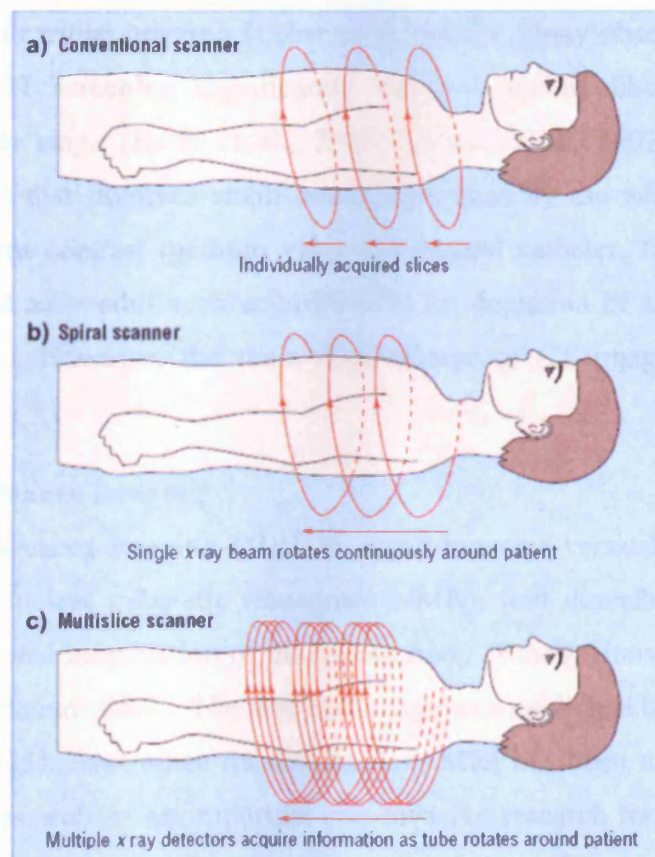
Different types of CT scanning procedures. (a) Axial CT, (b) Spiral CT and (c) Multi-slice CT (Garvey and Hanlon, 2002).
